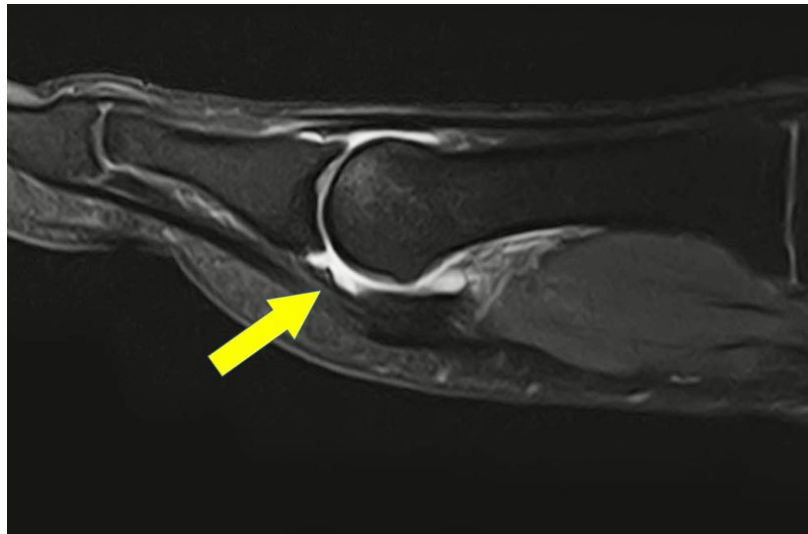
MRI arthrography of 1<sup>st</sup> MTP jt
